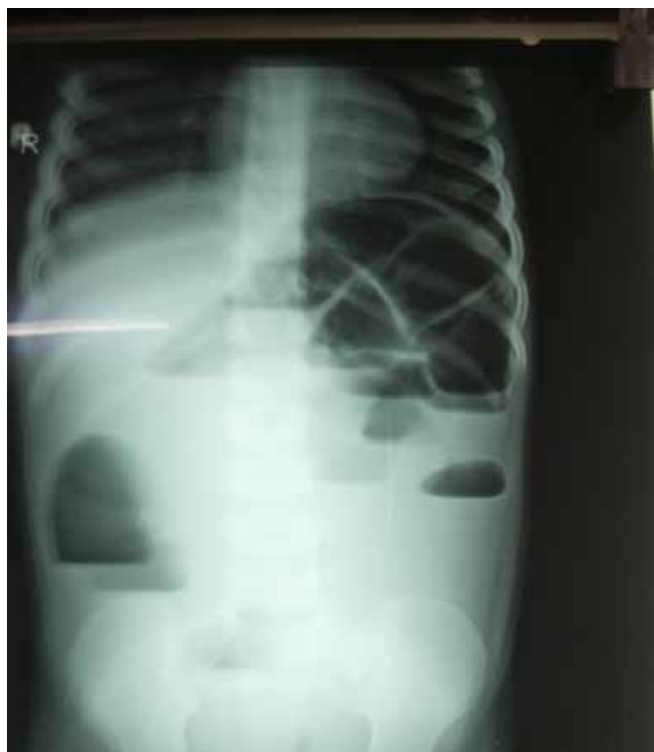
X-ray abdomen erect showed multiple air fluid levels.
